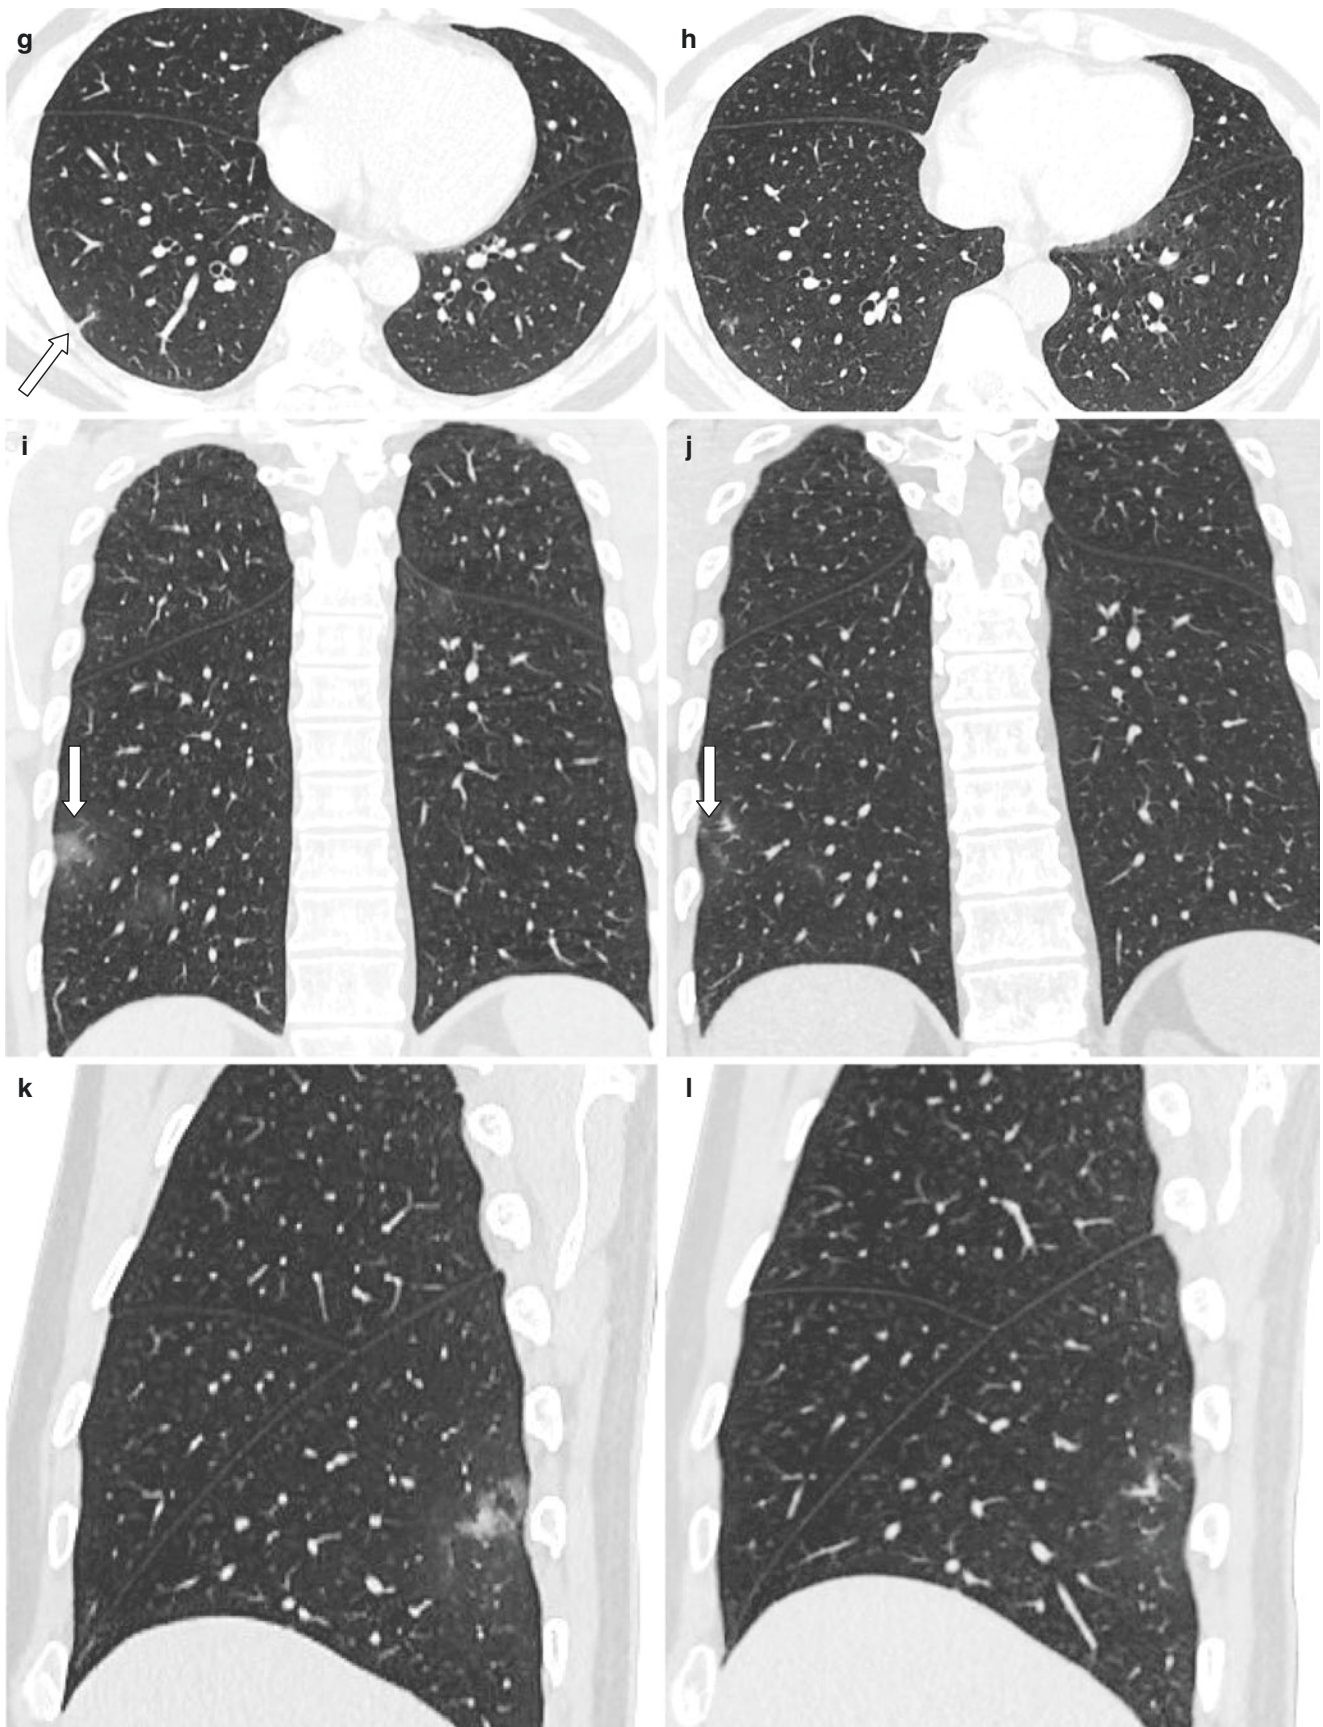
On 5 days after onset of symptoms, chest CT images showed no obvious abnormalities in both lungs (a, b). On 9 days after onset of symptoms, chest CT images showed patchy ground-glass opacities in the lower lobe of the right lung (c, d). On 12 days after onset of symptoms, chest CT images showed that the density of lesions in the lower lobe of the right lung was higher than before (e, f). On 22 days after
